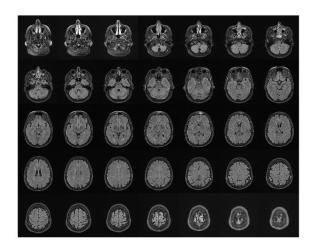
MRI FLAIR scan from patient 349 in 2014, 5 slices displayed. Exam performed at RAD, classified as A.
